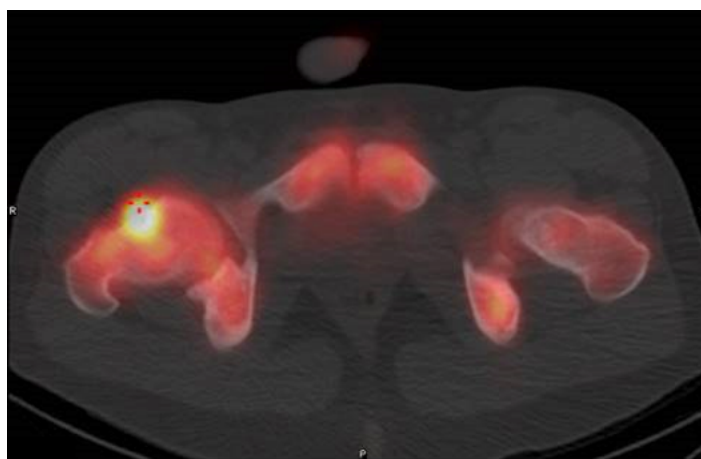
Skeletal scintigraphy with technetium 99m-HDP: Increased bone uptake at the femoral head-neck passage
